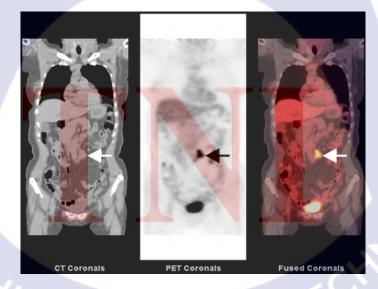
A 66-year-old female with endometrial cancer and PALN metastases (arrows) on FDG PET/CT images [2].
